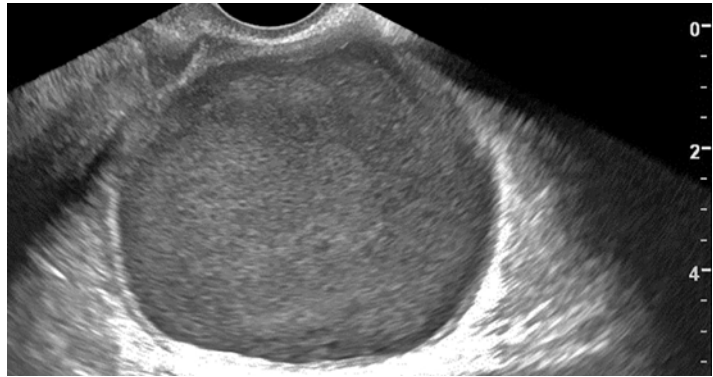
Endometrioma on ultrasonogram
